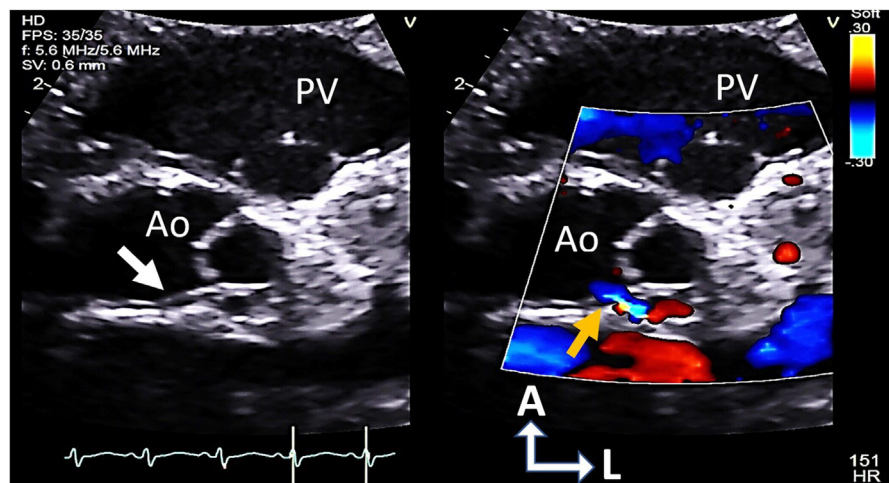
Parasternal short-axis view: two-dimensional image demonstrates quadricuspid leaflets with the smaller left posterior leaflet entrapping the left coronary ostium (white arrow). Color Doppler image demonstrates aliasing of flow as it crosses this rudimentary leaflet coursing to the left coronary artery (yellow arrow). A, Anterior; Ao, aortic valve; L, left; PV, pulmonary valve.
